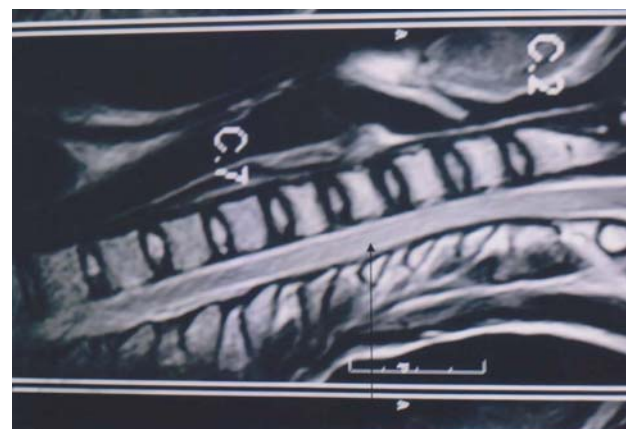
MRI showing swelling of spinal cord
